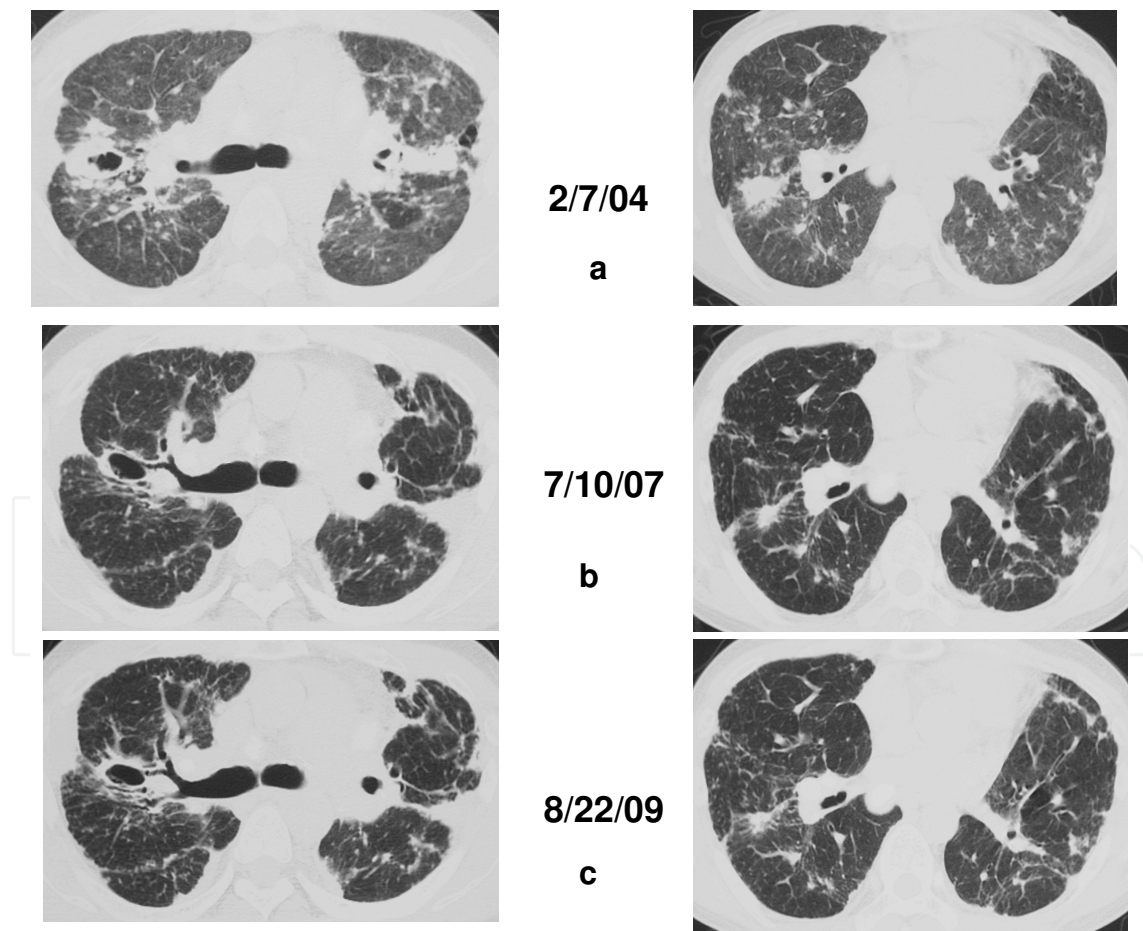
Longitudinal course of pulmonary fibrosis in patients with sarcoidosis: High-resolution CT findings a : when corticosteroids and methotrexate were introduced b: after 3 years of treatment c: after 5 years of treatment
